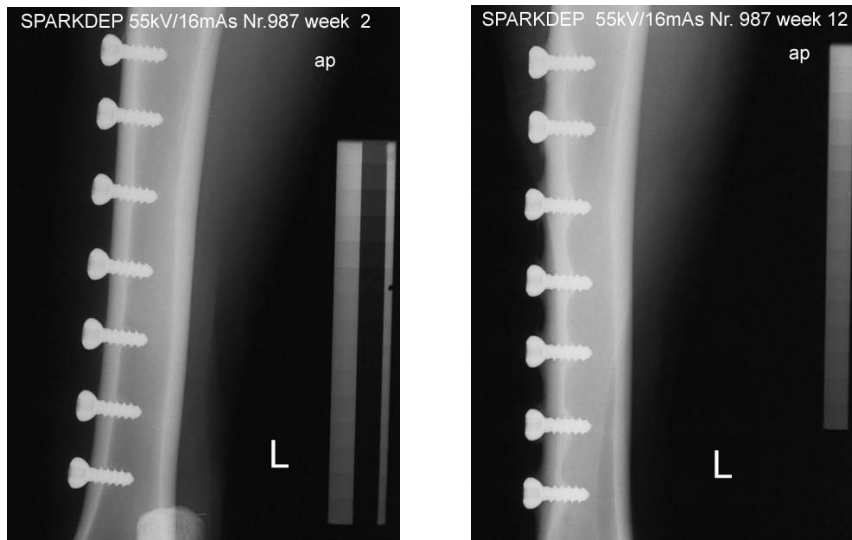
X-ray of all screws in left leg at week 2 after surgery showing little *de novo* bone formation at this resolution. b) X-ray of all screws in left leg at week 12 after surgery showing large amounts of *de novo* bone formation on the endosteal side.
